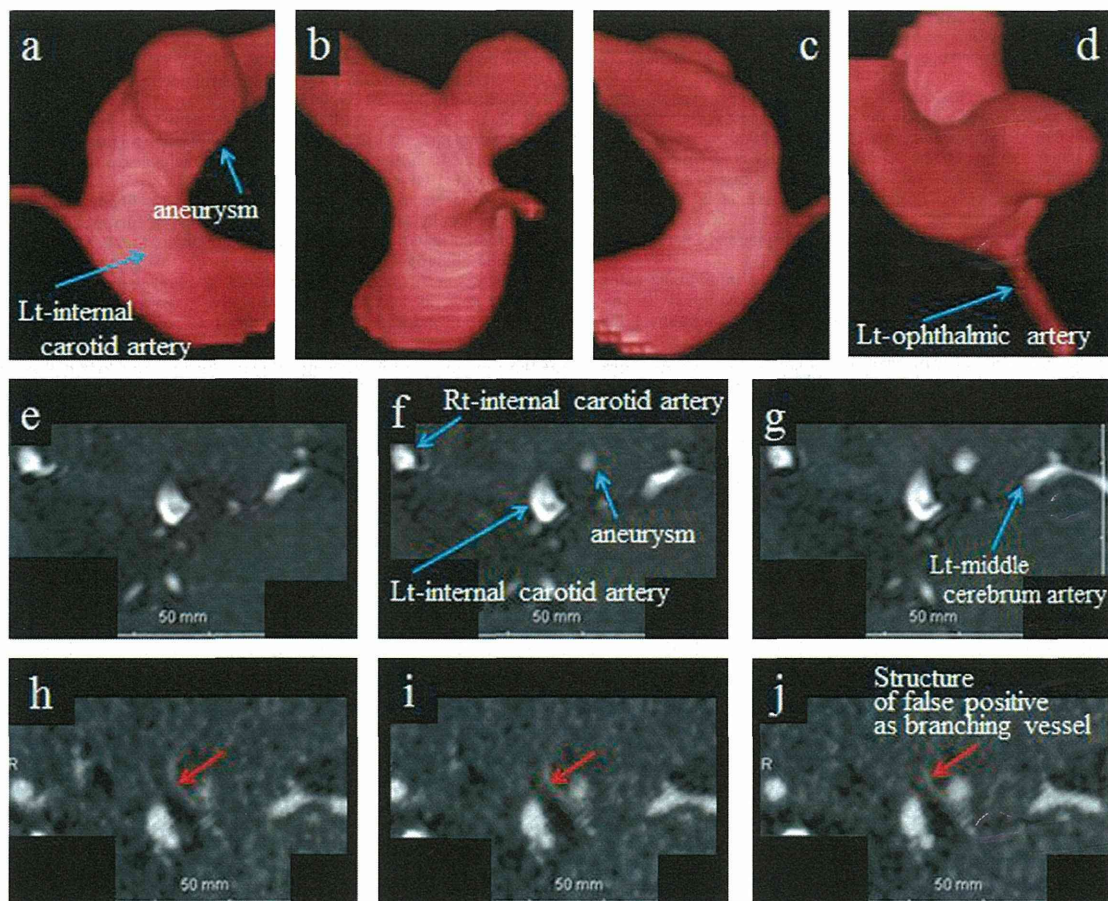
False positive on 'CTA-VR+source images' and true negative on 'MRA-VR+source images' observed in patient 35. No branch vessel arising from the aneurysm sac was observed on VR-rotational DSA in this patient. (a)–(d) VR-rotational DSA (a: left lateral view, b: frontal view, c: right lateral view, and d: 90° caudal rotation from front). (e)–(g) MRA source images. (h)–(j) CTA source images. The red arrow indicates a structure that was assessed as a branch vessel arising from the aneurysm sac but was in fact a vein. For subfigures (e)–(g) and (h)–(j), the image slices run superior to inferior, from left to right. (For interpretation of the references to color in this figure legend, the reader is referred to the web version of the article.)
